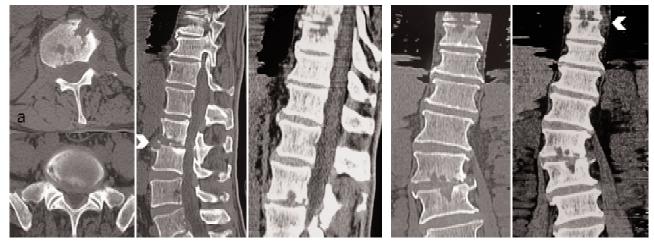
(a, b, c, d, e and f): transversal, sagittal and coronal CT images in bone and soft tissue algorithm show a narrowing of T9-T10 and L2-L3 disc, erosions of the adjacent endplates with presence of disc vacuum (arrow), new bone formation of the L2-L3 space with a "parrot beak appearance" and moderately swollen paravertebral soft tissues (arrowhead).
